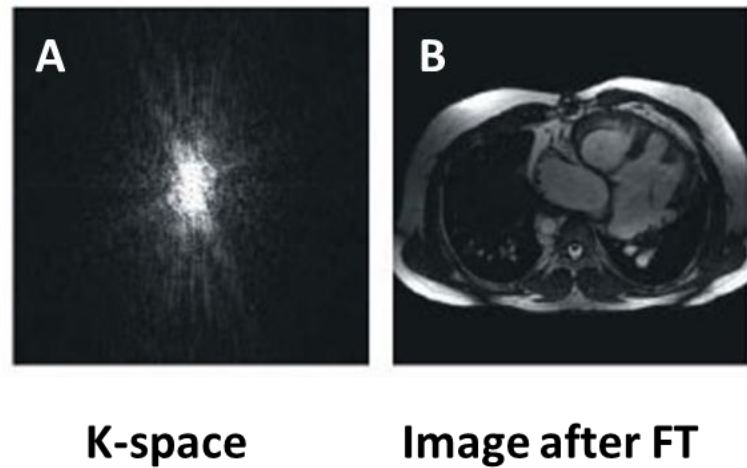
K-Space in MRI acquisition: (A) K-space and (B) its associate image after Fourier transform. Adapted from (Moratal 2008).
